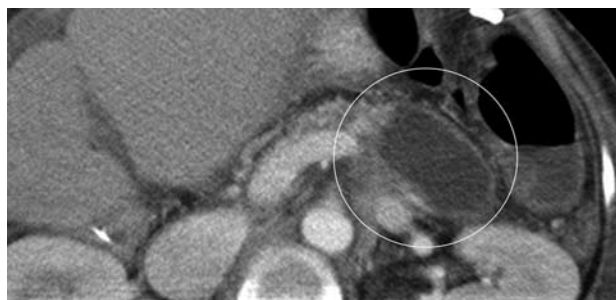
Computed tomography performed on postoperative day 13 showing fluid collection (circle) at the lower edge of the pancreas. The hematoma was considered to be ruptured.
